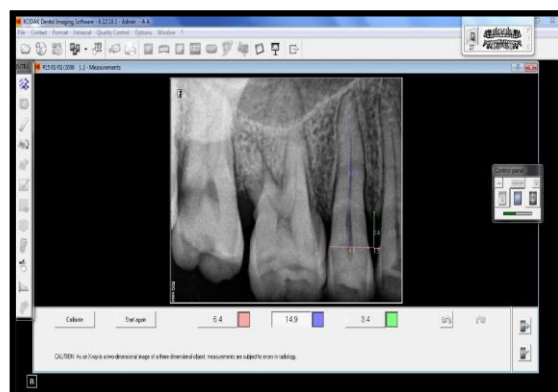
Calculation of radiographic alveolar bone loss using KODAK software.
